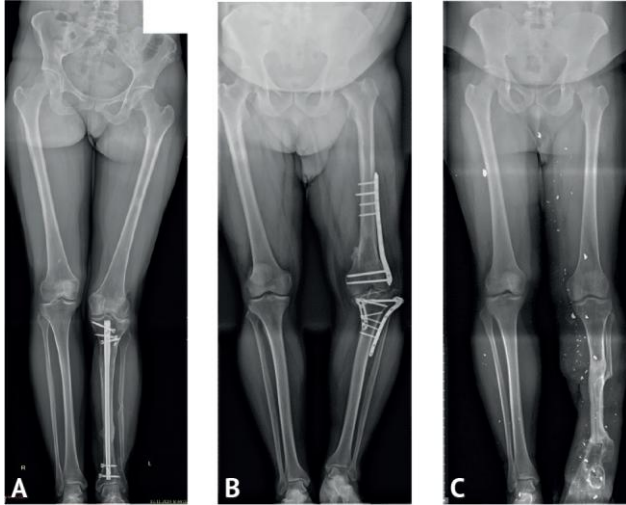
Typical examples (radiographs) of patients with post-traumatic shortenings of the lower extremities, characterized by the presence of unremoved implants and multicomponent deformities at the level of previously performed operations (A, B) and fragments of wounding shells (C)
